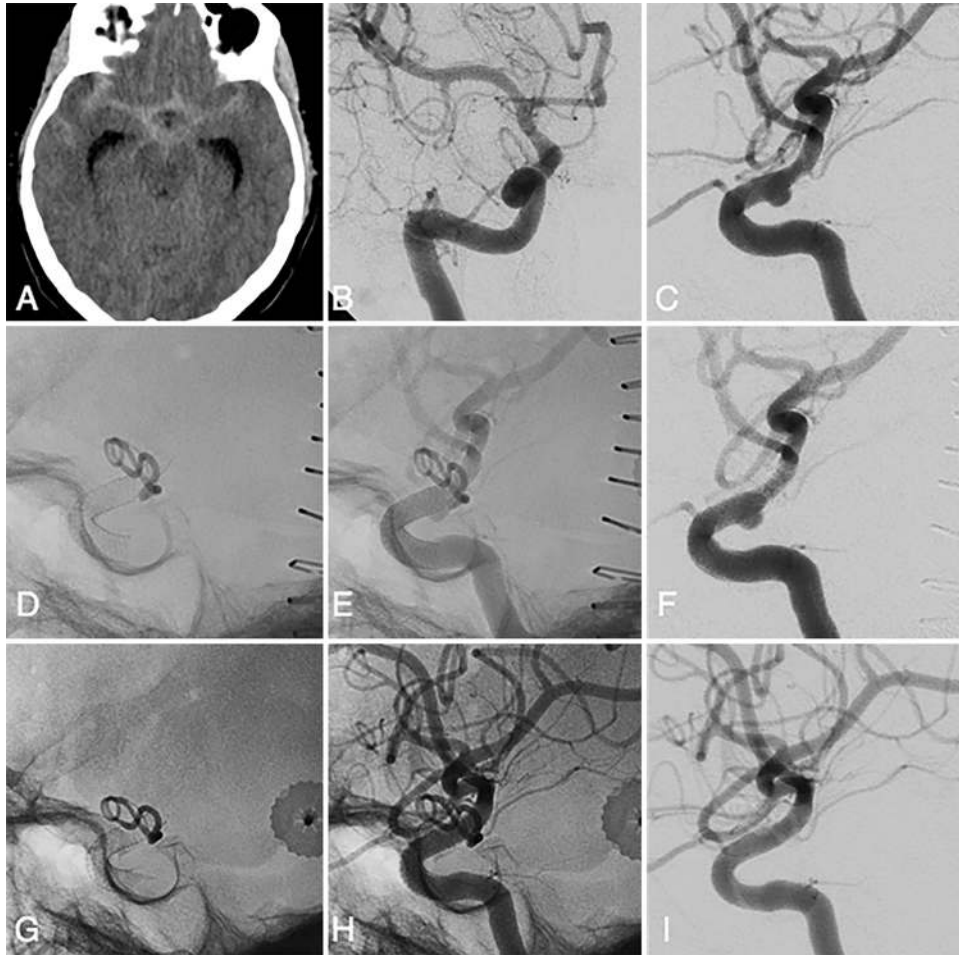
Case 7. Images from a 62-year-old woman who presented in a coma. Unenhanced axial CT (A) demonstrated a huge SAH in the basal and sylvian cisterns due to a ruptured BBA of the right ICA as shown in frontal and lateral angiograms (B and C). The patient underwent surgical exploration to clip the aneurysm. Clipping was unsuccessful and the patient was transferred to the angiography suite. Unsubtracted and subtracted lateral angiograms (D–F) after deployment of a PED in the right ICA show the correct position of the device and the surgical clip. Six-month angiographic follow-up (G–I) show the complete exclusion of the aneurysm.
